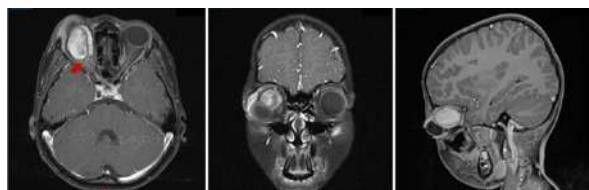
Contrast-enhanced cranial and orbital MRI showed a heterogeneously enhancing mass diffusely involving the intraorbital and canalicular segments of the right optic nerve (red arrow).
